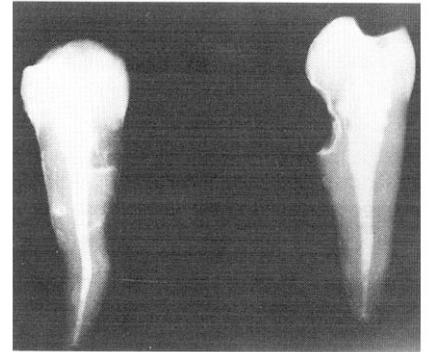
Radiograph of premolar shows outline of root canal before instrumentation. Left, faciolingual view, right, mesiodistal view.
